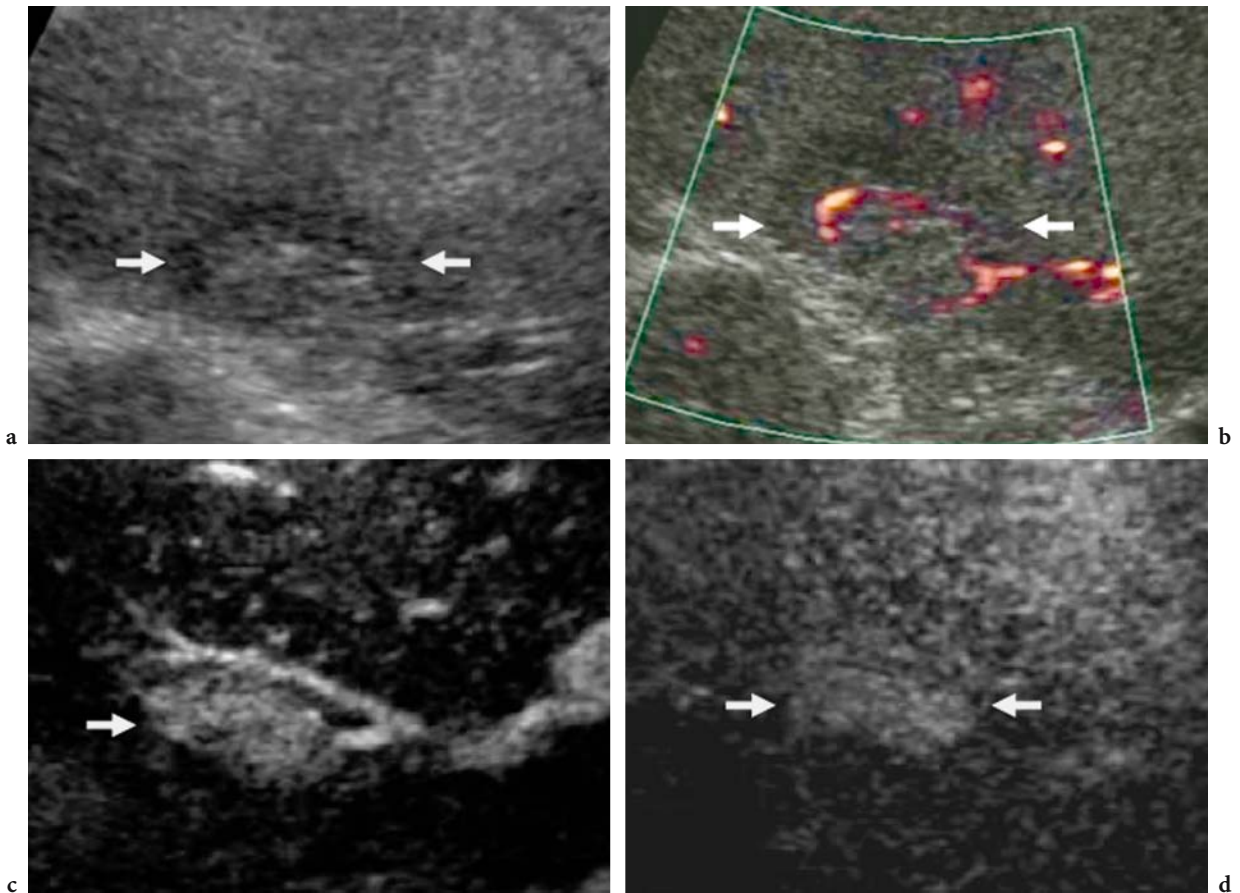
Hypervascular hemangioma: diffuse contrast enhancement. a Baseline US. A heterogeneous lesion (*arrows*) is demonstrated in a bright liver with some intratumoral vessels on baseline power Doppler US (b). c, d Contrast-enhanced US. Contrast-specific mode: Pulse Inversion Mode (Philips-ATL, WA, USA) with low acoustic power insonation. Diffuse homogeneous contrast enhancement is demonstrated during the arterial phase (c) and persists during the late phase (d), with an isoechoic appearance in comparison to the adjacent liver parenchyma. Hemangioma was proved by US-guided biopsy.
